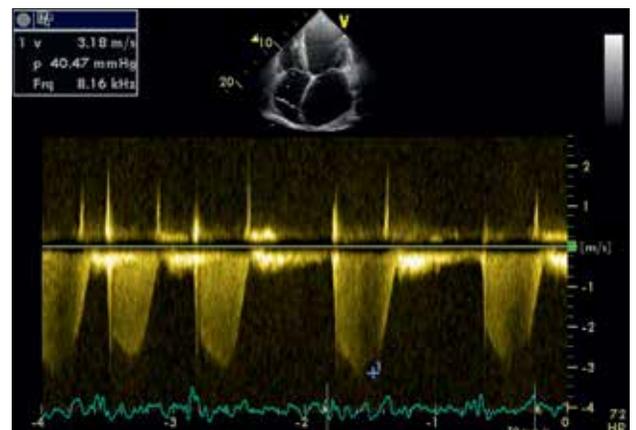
Transthoracic echocardiography. Moderate tricuspid regurgitation with elevated right ventricle systolic pressure 55 mm Hg
